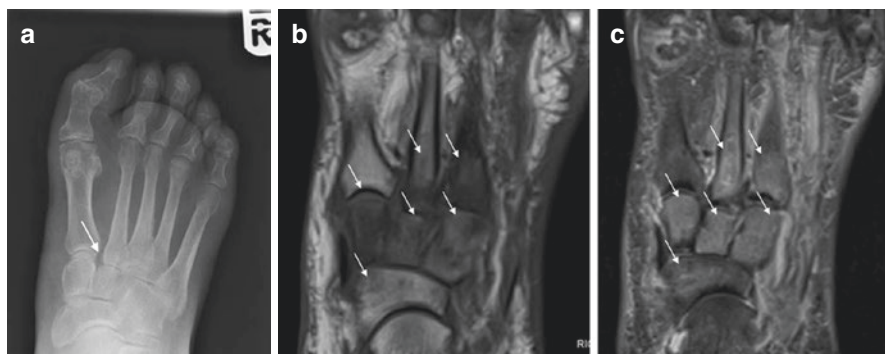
Right stage 0 Charcot foot (X-ray negative, MRI positive). A patient presented with a painful red swollen right foot 2 °C warmer compared with the contralateral foot. C-reactive protein was 9 mg/L. (a) dorsoplantar radiograph shows mid-foot soft tissue swelling with only a very subtle step at the medial margin of the second metatarsal-tarsal joint (arrow) (b) axial T1 and (c) STIR MR imaging show prominent bone marrow oedema (reduced signal on T1 and increased signal on STIR) within the proximal diaphyses of the second and third metatarsals, the cuneiforms, and the navicular (arrows)
